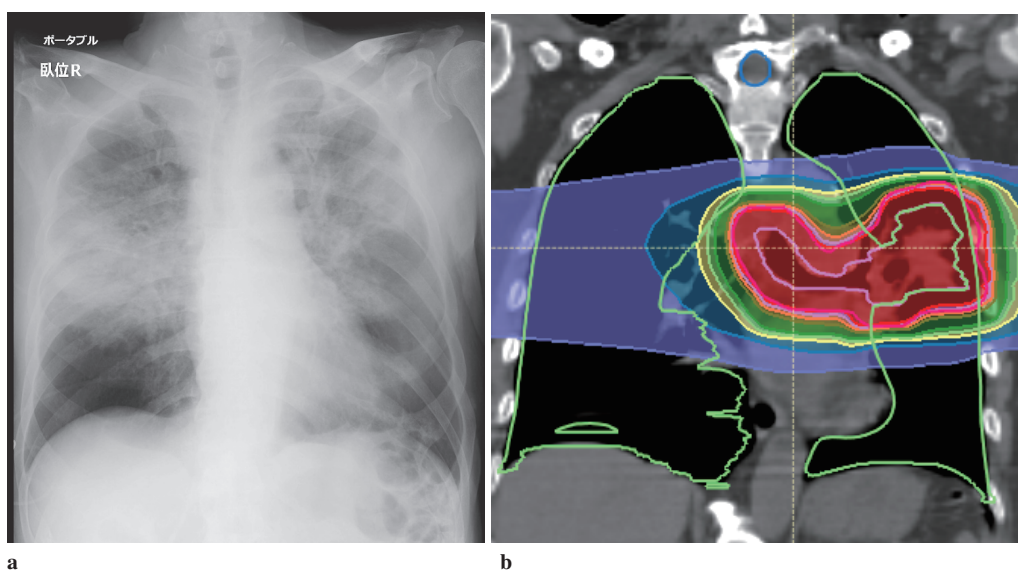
CT image on day 52 and dose distribution
